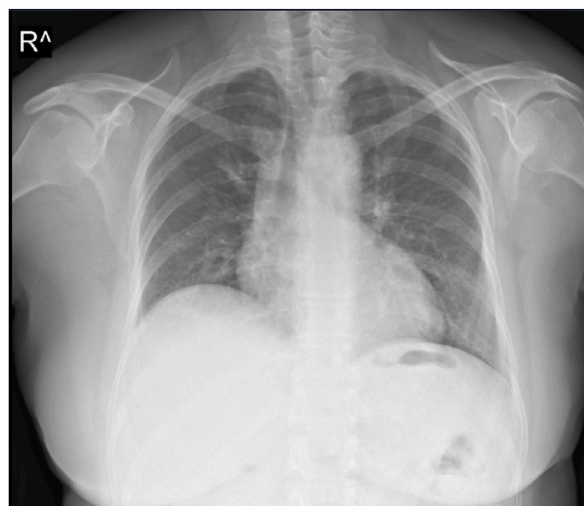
X-ray showing marked resolution of previously seen pulmonary infiltrates after Pulse Solumedrol and Cyclophosphamid treatments.
